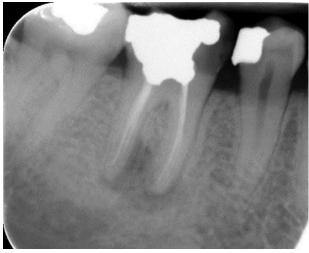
A pre-operative periapical radiograph showing poor quality of endodontic treatment and a defective restoration
